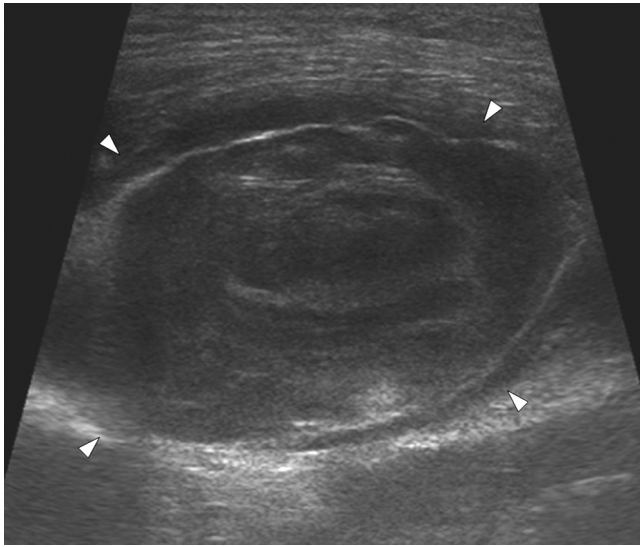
Rectus sheath hematoma. There is a large oval-shaped heterogeneous hypoechoic lesion (white arrowheads) within the rectus sheath that is displacing the rectus muscle peripherally. The features are compatible with rectus sheath hematoma. No colour flow was present on colour-Doppler imaging. Clinical and ultrasound appearances were compatible with a rectus sheath hematoma.
